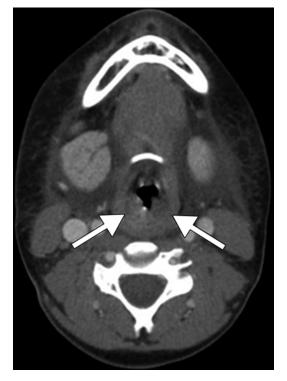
Diffuse AACE inhibitor induced angioedema. Axial contrast-enhanced CT image shows circumferential mucosal pharyngeal swelling (*arrows*) and diffuse stranding of the parapharyngeal and subcutaneous fat bilaterally
